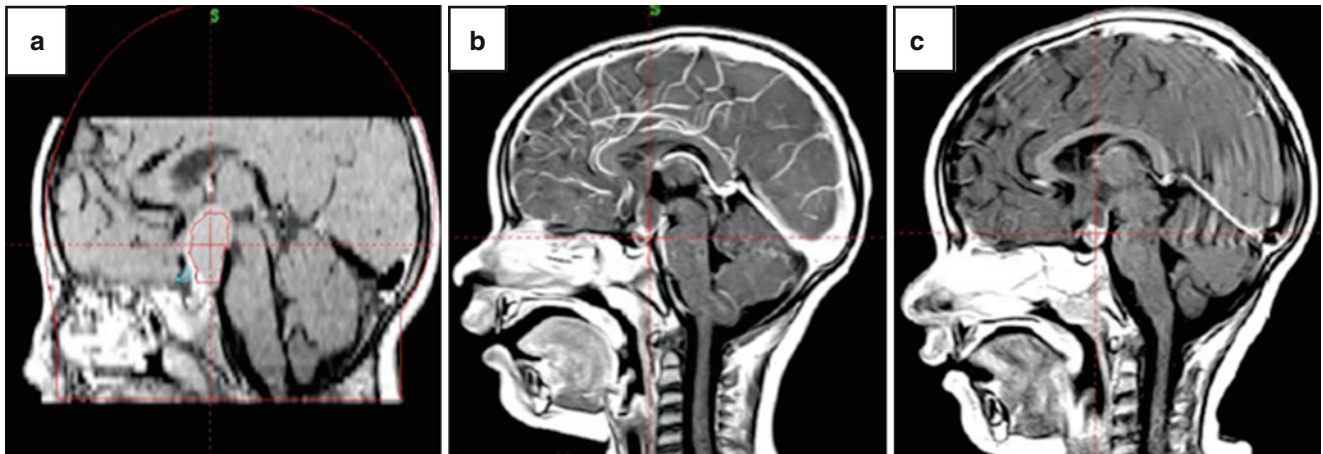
Contrast-enhanced sagittal T1-weighted MRI in a 33-month-old child with a mixed-type craniopharyngioma treated solely with GKS. (a) At the time of radiosurgery, the volume of the tumor was 3.0 cm³. At
